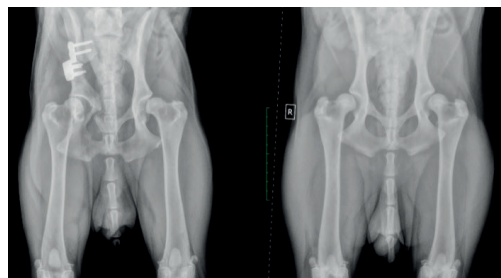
Internal plate fixation in iliac fractures with concurrent mild coxo-femoral subluxation after surgery. 60 days follow-up radiograph imaging demonstrates complete healing after the second PRP administration, with the joint showing no further signs of damage or abnormality
